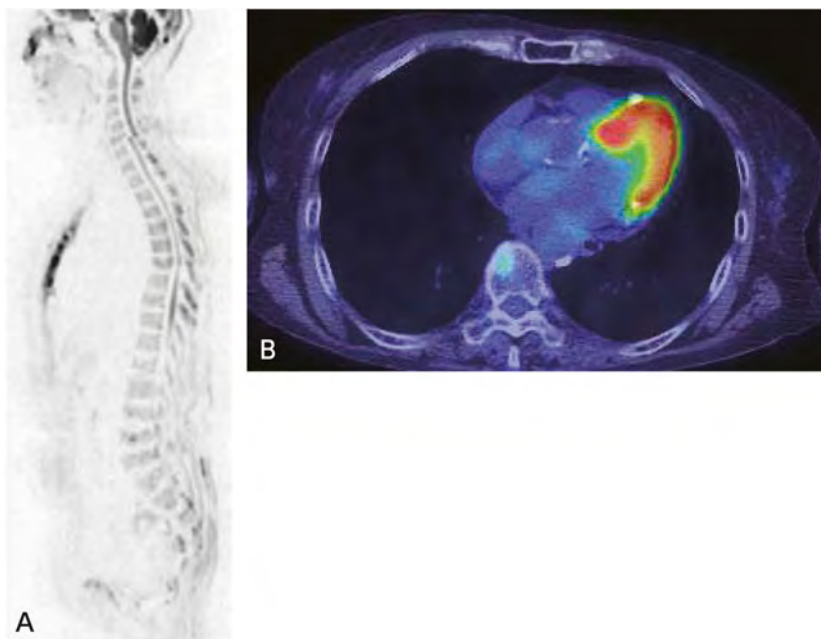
Evaluation of MM activity after treatment with FDG-PET/CT
